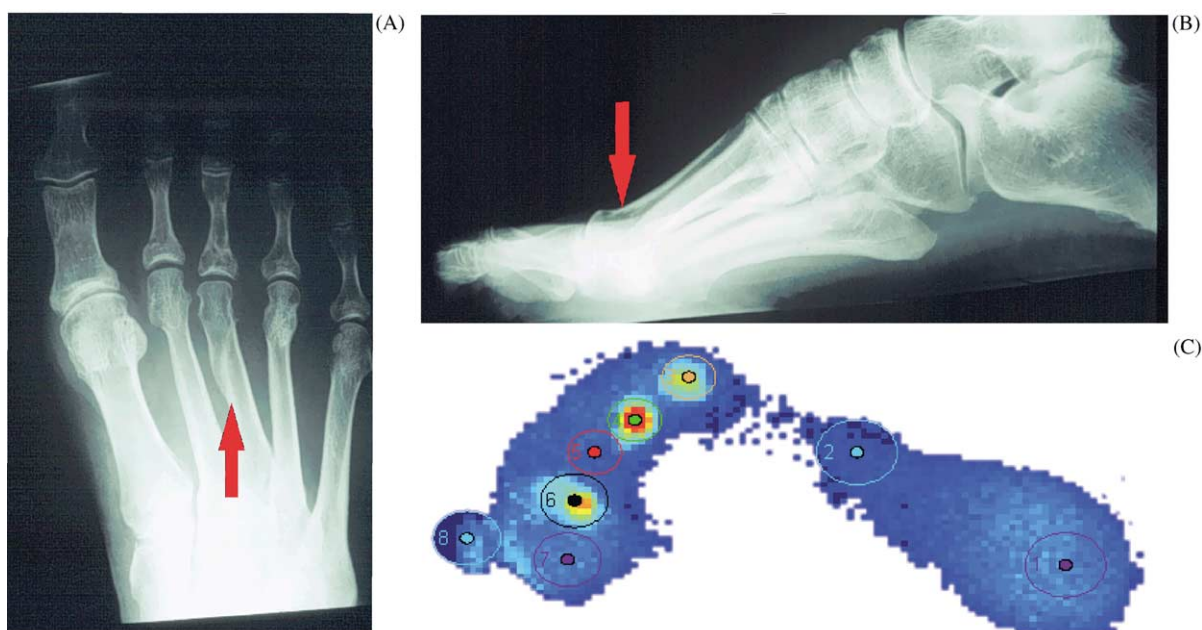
Case A: (A) A/P weight-bearing X-ray, (B) Med/Lat weight-bearing X-ray and (C) dynamic foot pressure print.
